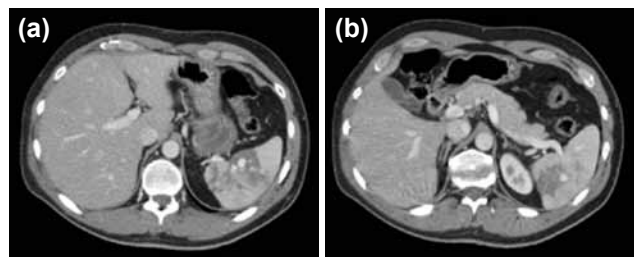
(a, b) Abdominal CT with contrast. There are hypodense areas diffusely throughout the majority of the spleen and a subcapsular hematoma with active bleeding. There is no free peri-splenic fluid.
